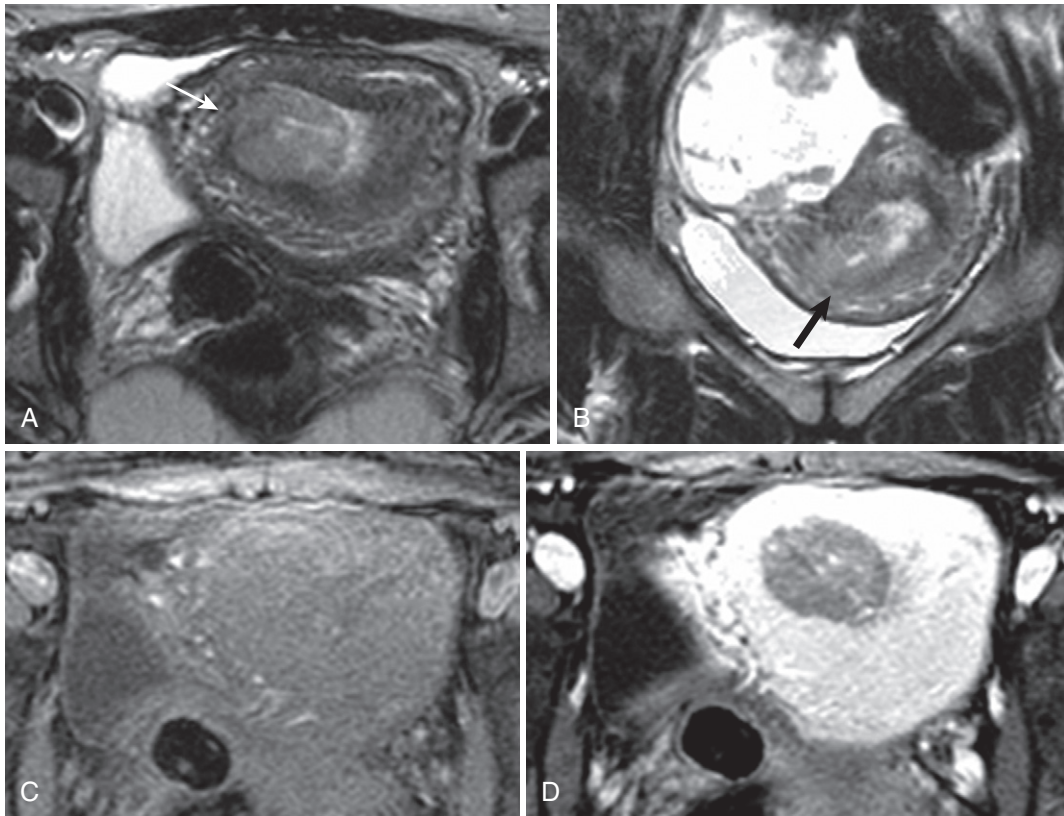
Endometrial carcinoma without and with myometrial invasion. Axial (A) and coronal (B) T2-weighted images show a mostly well-defined endometrial mass (*thin arrow* in A) focally invading the inner myometrium (junctional zone; *thick arrow* in B). Precontrast (C) and postcontrast (D) images reflect lesion hypovascularity and render exquisite tissue contrast, confirming absence of deep myometrial invasion.
